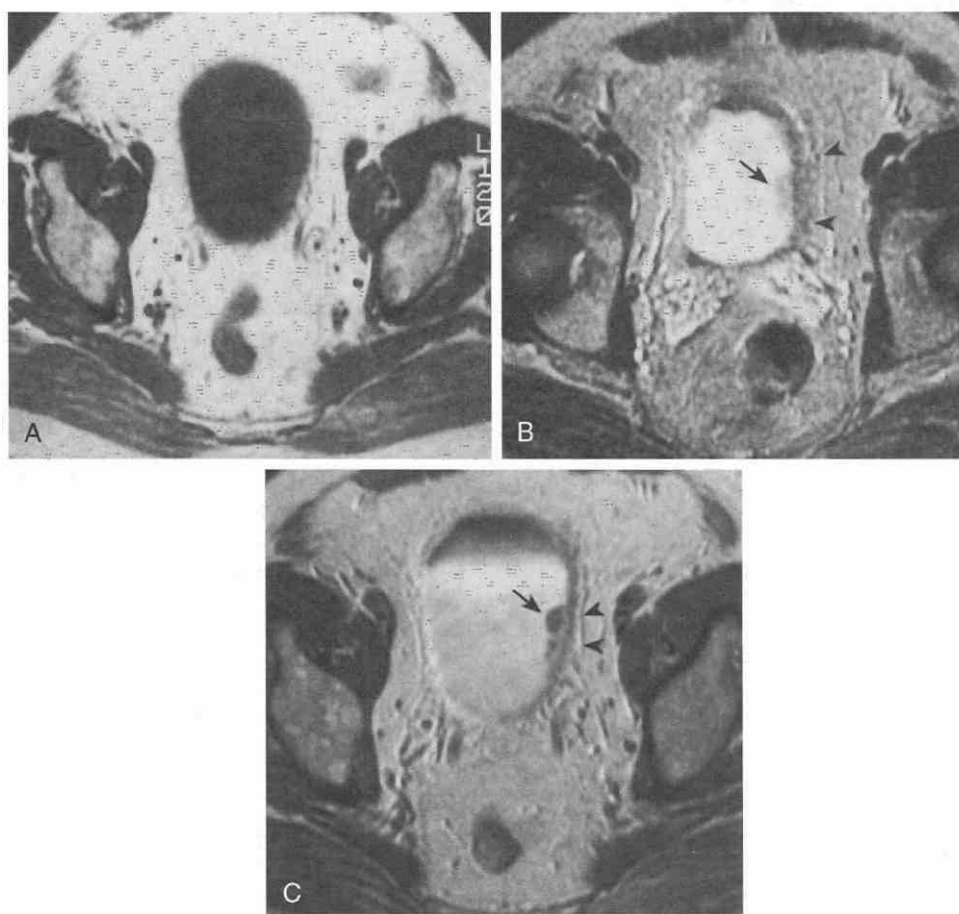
Superficial bladder carcinoma. A, Axial T1-weighted, spin-echo image (TR = 600 msec, TE = 18 msec) shows no evidence of spread of tumor into the perivesicular fat. The tumor itself as well as the bladder wall is poorly seen, however, because of the poor contrast between the urine and the tumor or the bladder wall. B, The T2-weighted, spin-echo image (TR = 2500 msec, TE = 80 msec) better demonstrates the tumor (arrow). Low-signal-intensity bladder muscularis (arrowheads) is seen underneath the polypoid tumor, indicating the superficial tumor. C, After administration of gadolinium, the axial T1-weighted spin-echo image shows the gadolinium within the urinary bladder outlining the tumor (arrow). The bladder wall enhances slightly and forms a continuous band (arrowheads) underneath the tumor, again verifying the superficial extent of the tumor.
